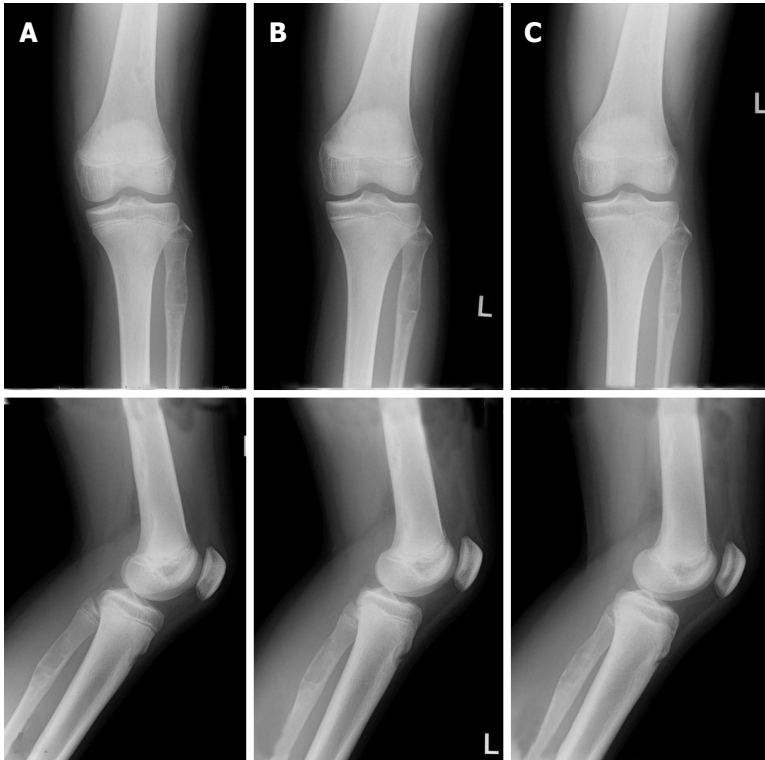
Plain radiographs of non-ossifying fibromas in the femur and the fibula of a 13-year-old female. The radiographs reveal an osteolytic lesion in the proximal fibula, as well as a NOF in the distal femur (A). Radiographs taken after 9 mo (B) and 1 year and 9 mo (C); the femoral and fibular lesions ossified (plain radiographs: Anteroposterior view, top; lateral view, bottom).
